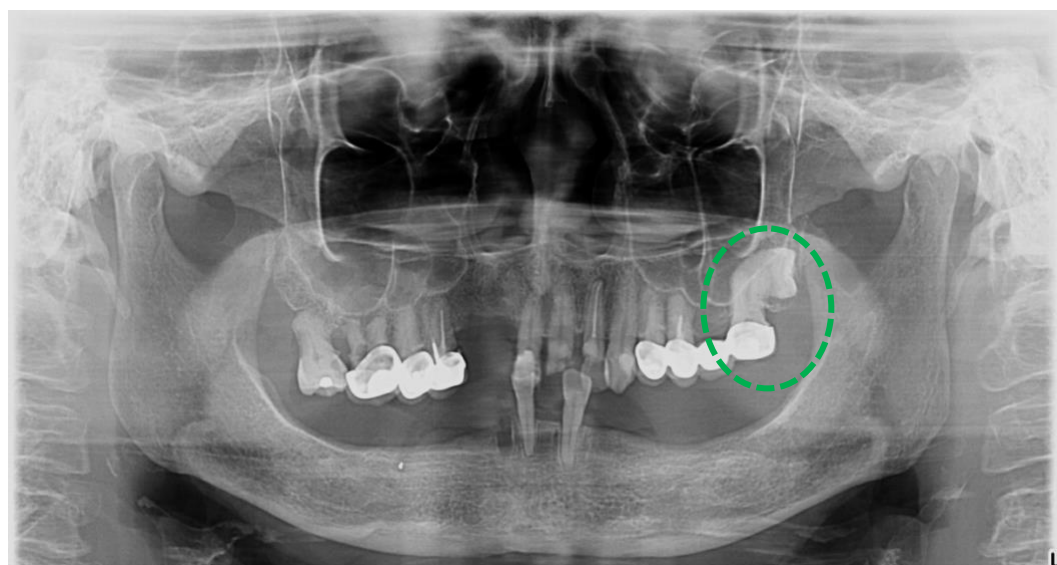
Incidental finding of concrescence on a panoramic radiograph involving the impaction of tooth 28. The root of tooth 28 appears to be fused with the root of tooth 27 (dashed green circle)
